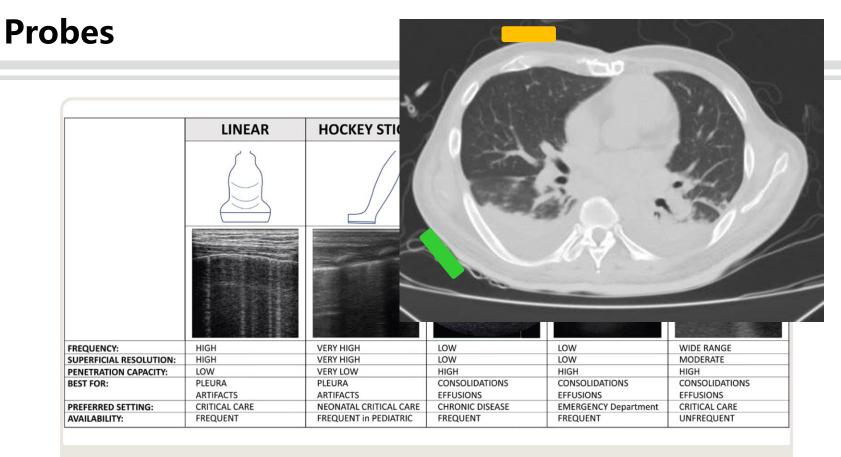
Main features of the ultrasound transducers most commonly used for lung assessment.
